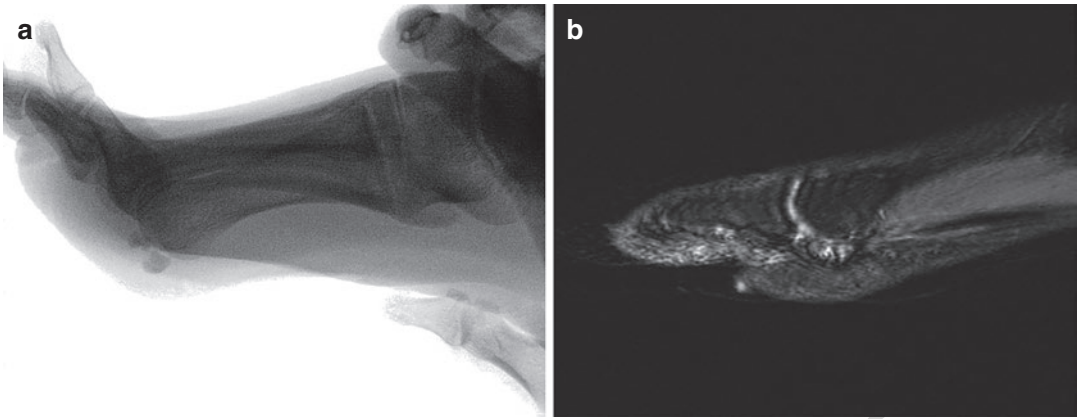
(a) Lateral foot fluoroscopic image demonstrating fracture of the tibial sesamoid with displacement upon dorsiflexion, (b) sagittal T2 MRI images showing avascular necrosis of the sesamoid
